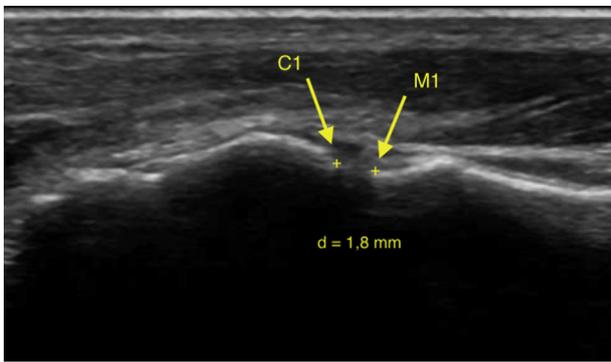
Ultrasound measurements at rest. C1: edge of the joint surface of the medial cuneiform; M1: edge of the joint surface of the first metatarsal; d: distance between C1 and M1 in the resting position (resting plantar TMT1 gap).
